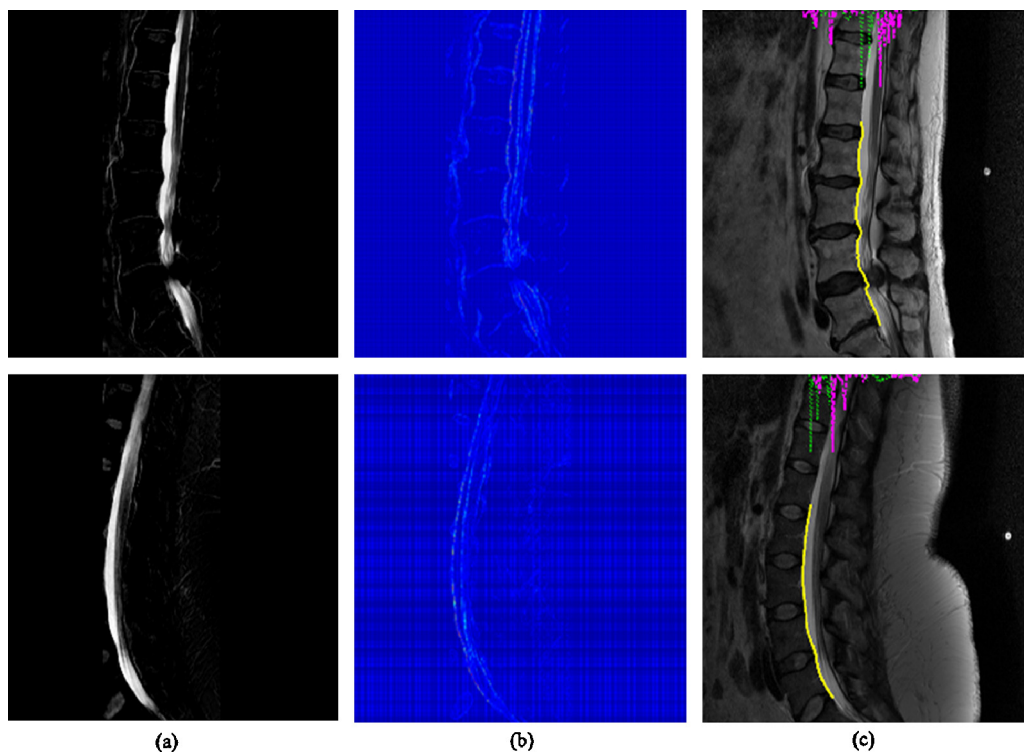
The whole process of the left boundary extraction of the spinal canal. (a) The absolute pixel intensity difference between T1-weighted and T2-weighted images, (b) the gradient magnitude of the pixel intensity difference, and (c) the boundary output and the profile of gradient magnitude. The green profile represents the gradient magnitude, $\|\nabla I(x, y)\|$, at the first layer while the magenta profile shows the gradient magnitude at the last layer. Note that in (b), the larger magnitude maps to a brighter color. (For interpretation of the references to color in this figure legend, the reader is referred to the web version of the article.)
